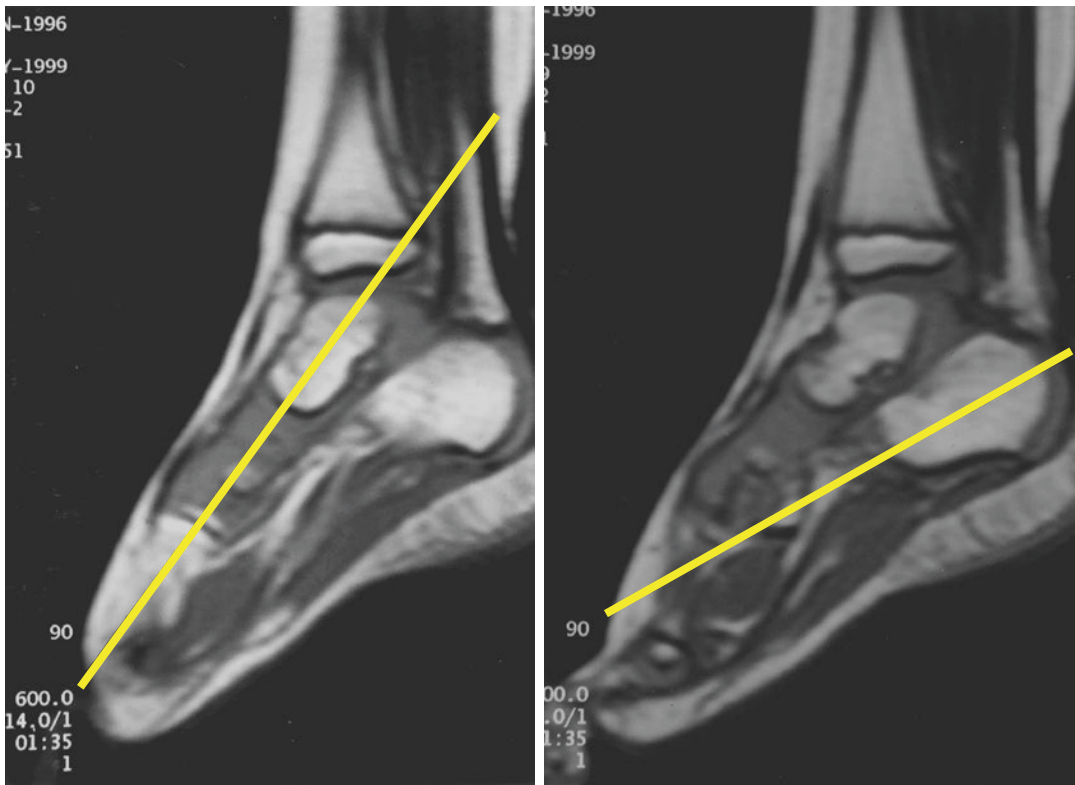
Lateral MRI talo-calcaneal angle
